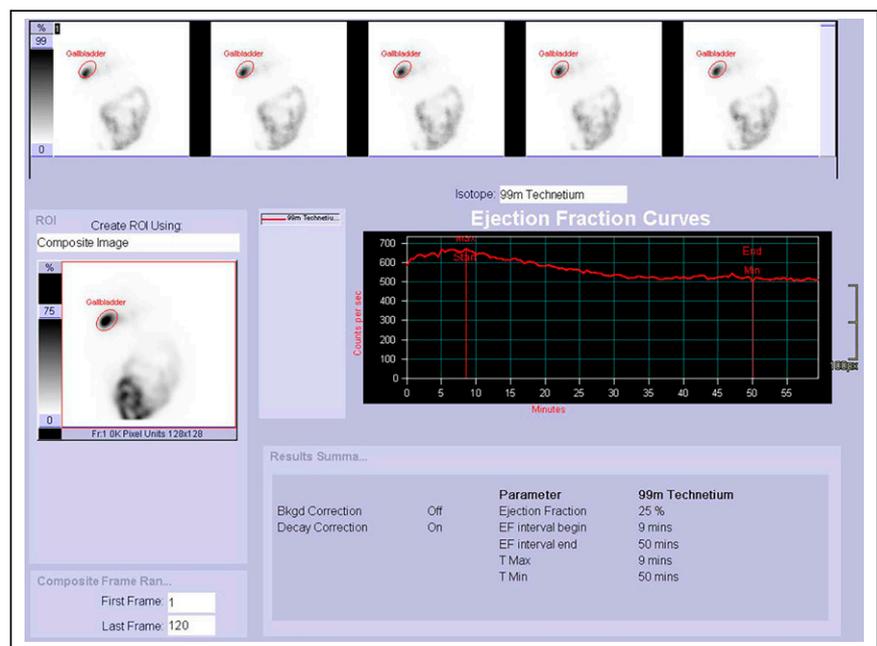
Ensure Plus hepatobiliary scintigraphy results for patient with chronic functional gallbladder disorder (gallbladder ejection fraction, 25%). Appropriate gallbladder ROI placement is shown. Ejection fraction was calculated from demonstrated time-activity curve. Low ejection fraction (<33%) is consistent with chronic functional gallbladder disorder. EF = ejection fraction; Fr:1 = frame 1; T max = time of maximum counts/s; T min = time of minimal counts/s.
